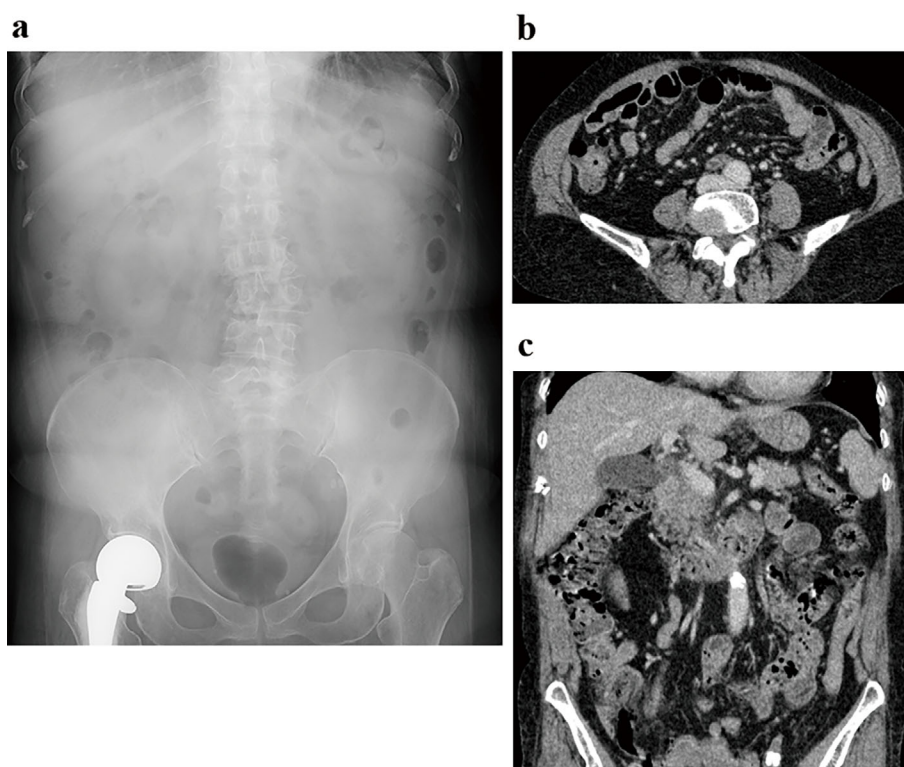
No findings of ileus or a residual foreign body were noted on abdominal X-ray (a) and CT images (b, c) after enteroscopy treatment.
